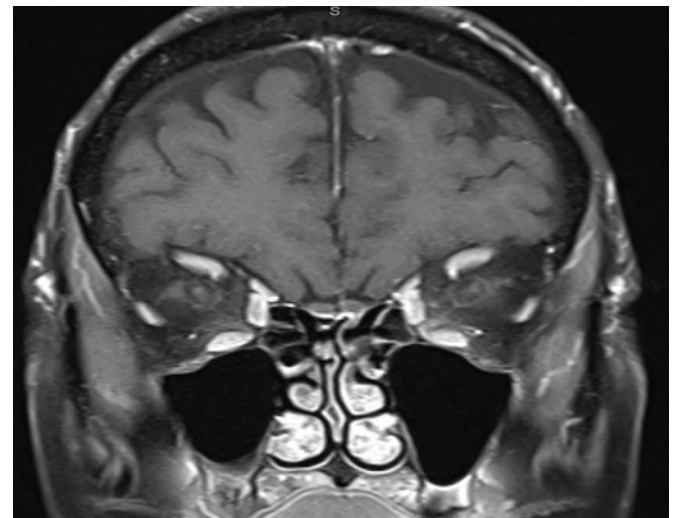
T1-weighted coronal MRI of sagging eye syndrome. Note inferior displacement of the lateral rectus muscles consistent with the sagging eye syndrome diagnosis.
